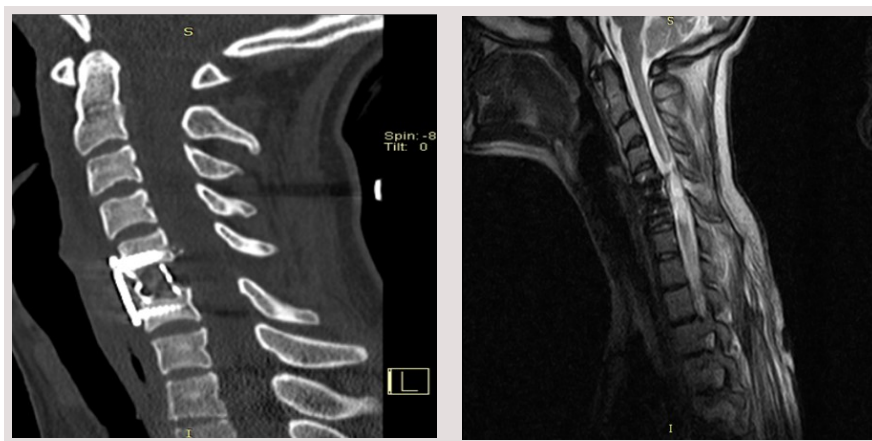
Sagittal CT view of the Cervical. Showing the instruments in place from next postoperative day. And 3 months postoperative MRI showing myelopathy at the level of trauma*
